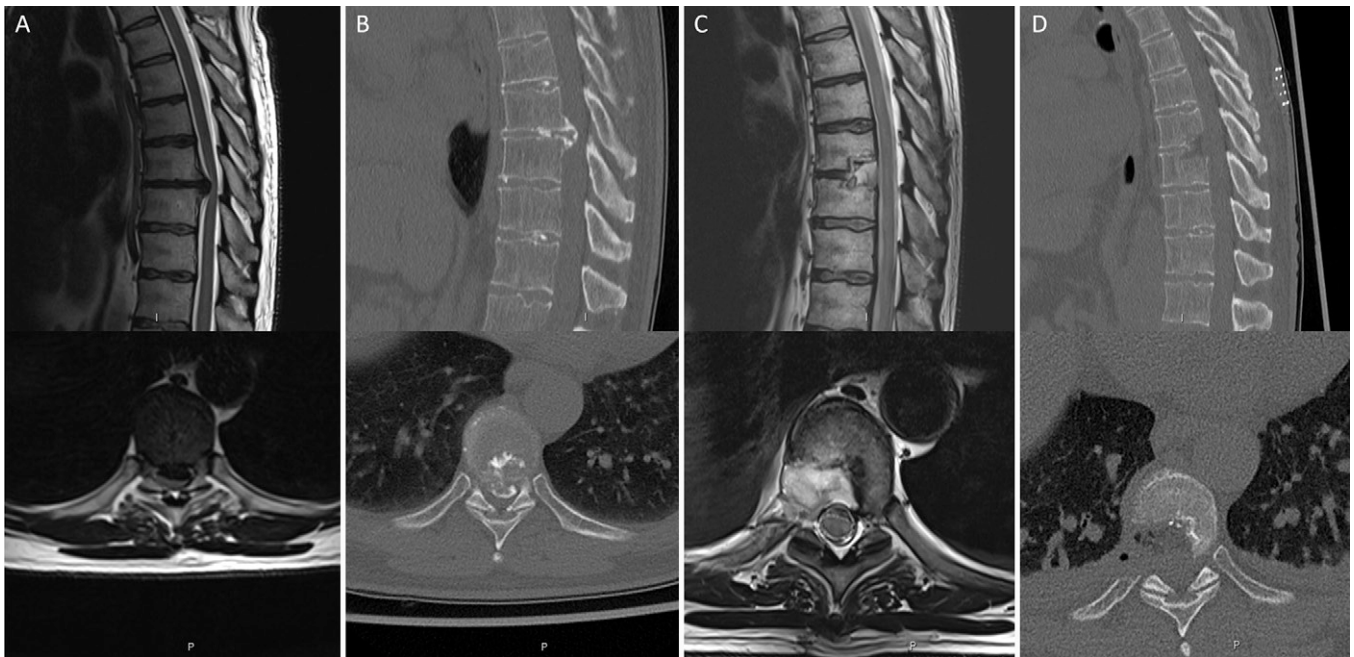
Case 5. A: Preoperative sagittal (upper) and axial (lower) T2-weighted MRI shows the large central disc prolapse with severe cord compression. B: Preoperative sagittal (upper) and axial (lower) CT shows the calcification of the disc prolapse. C: Postoperative sagittal (upper) and axial (lower) T2-weighted MRI shows decompression of the cord and no T2-weighted MRI signal change within the cord. D: Postoperative sagittal (upper) and axial (lower) CT shows the bony access and decompression of the spinal canal.
